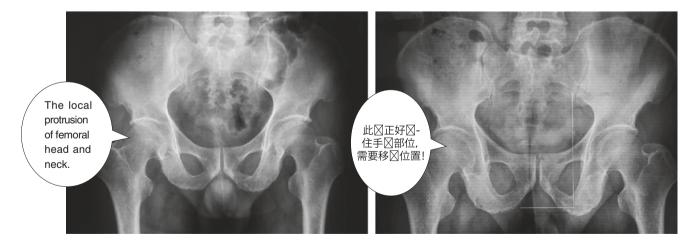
X-ray indication of hip joint front and back before and after surgery. The surgery rectified the "Cam" deformity at the right femoral head and neck
